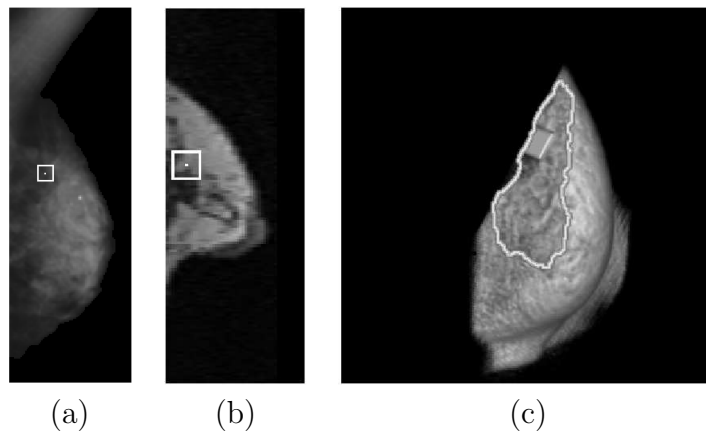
Example of X-ray to MR correspondence using internal structures: a point from (a) the X-ray image is matched to a point in the MR volume seen here as (b) a single slice and (c) a rendered volume. In all three cases the corresponding point is at the center of the square.
